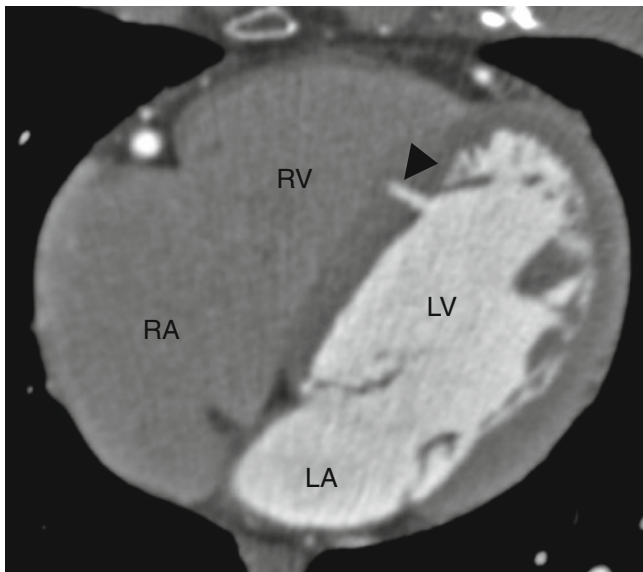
Type 4 (muscular) VSD. Transverse CT demonstrates contrast agent in the muscular interventricular septum (*black arrowhead*). Note the rim made up of septal muscle. *RA* right atrium, *RV* right ventricle, *LA* left atrium, *LV* left ventricle
